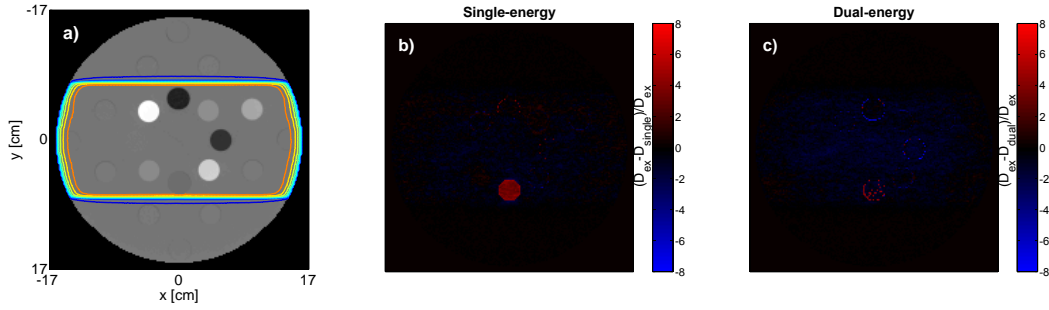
Dose distributions in the exact geometry for two parallel-opposed 18 MV beams (a). The dose calculation errors in the single-energy CT geometry (b) and the dual-energy CT geometry (c).
